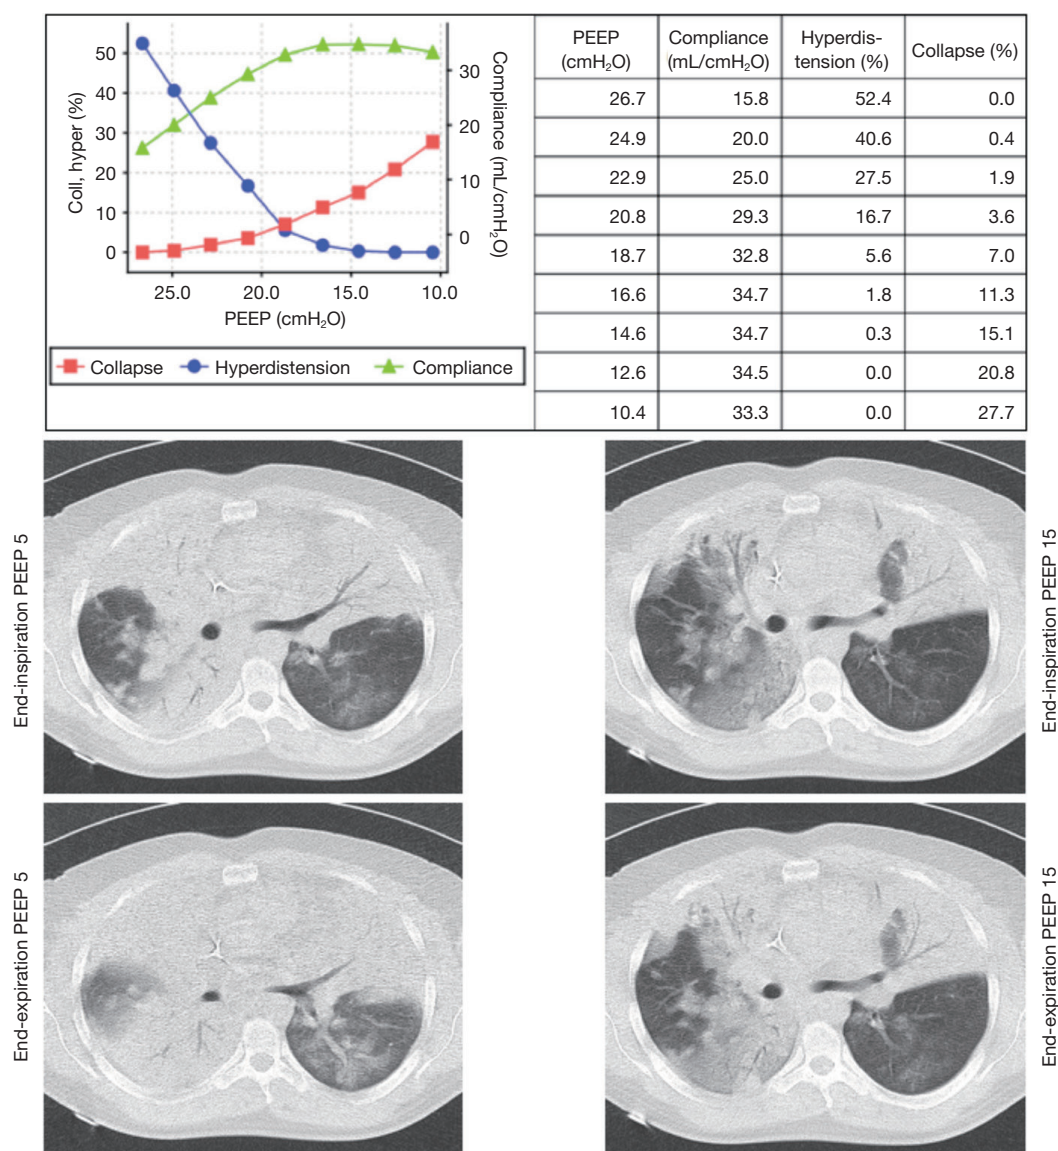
Computed tomography (CT) and electrical impedance tomography (EIT) assessments in an ARDS patient in prone positioning. On the top, there is a positive end-expiratory pressure (PEEP) titration according EIT. On the bottom, there are CT slices taken at end-expiratory and end-inspiratory with PEEP 5 and PEEP 15 cmH₂O. In this patient with highly recruitable lung, the use of PEEP 15 was associated to better respiratory mechanics (higher compliance and lower driving pressure), and higher recruitment and lower tidal recruitment/derecruitment in comparison with PEEP 5. ARDS, acute respiratory distress syndrome.
